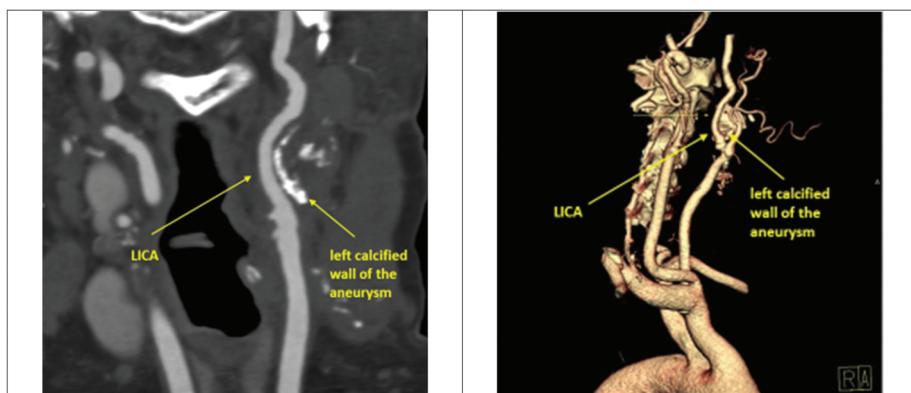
Image of the angio-CT LICA examination 6 months after surgery. Source: clinical material of M. Trystula
